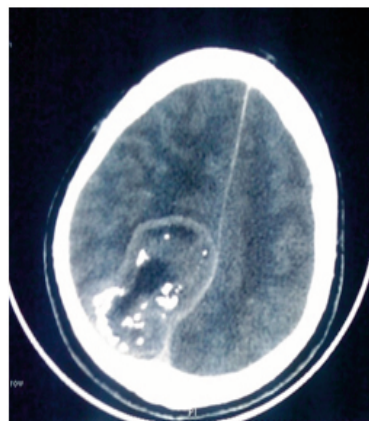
Axial CT Scan showing calcifications inside the lesion
